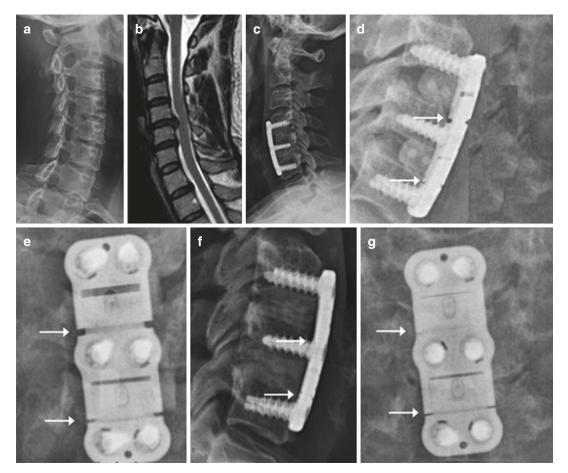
Plain neutral oblique radiograph (a) demonstrating overall cervical lordosis. Sagittal T2-weighted MRI (b) demonstrating multiple levels of cervical stenosis, most prominent at C3/C4 with T2 cord signal change behind the C4 vertebral body. A C4–C6 ACDF was performed (c). A semiconstrained translational plate was
